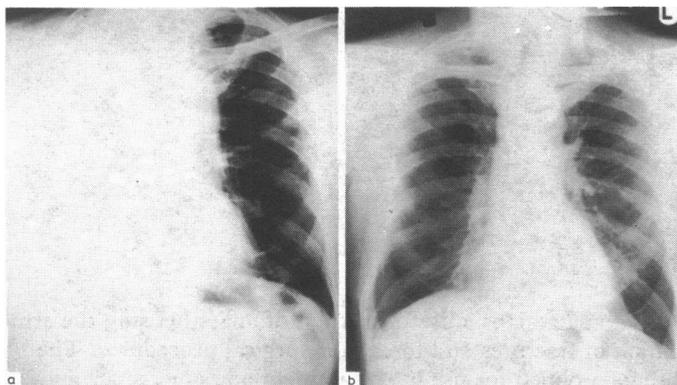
Chest radiographs of the patient in case 2, showing (a) collapsed right lung at presentation; (b) re-expanded right lung after treatment.
